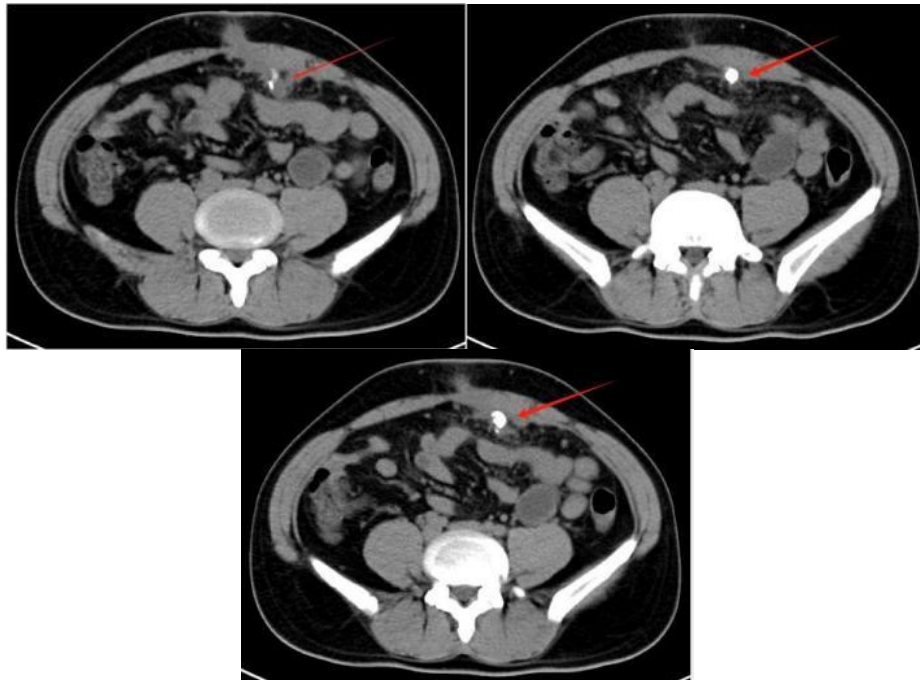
CT showed a high-density shadow near the abdominal wall at the lower left of the navel (the position pointed by the arrow).
